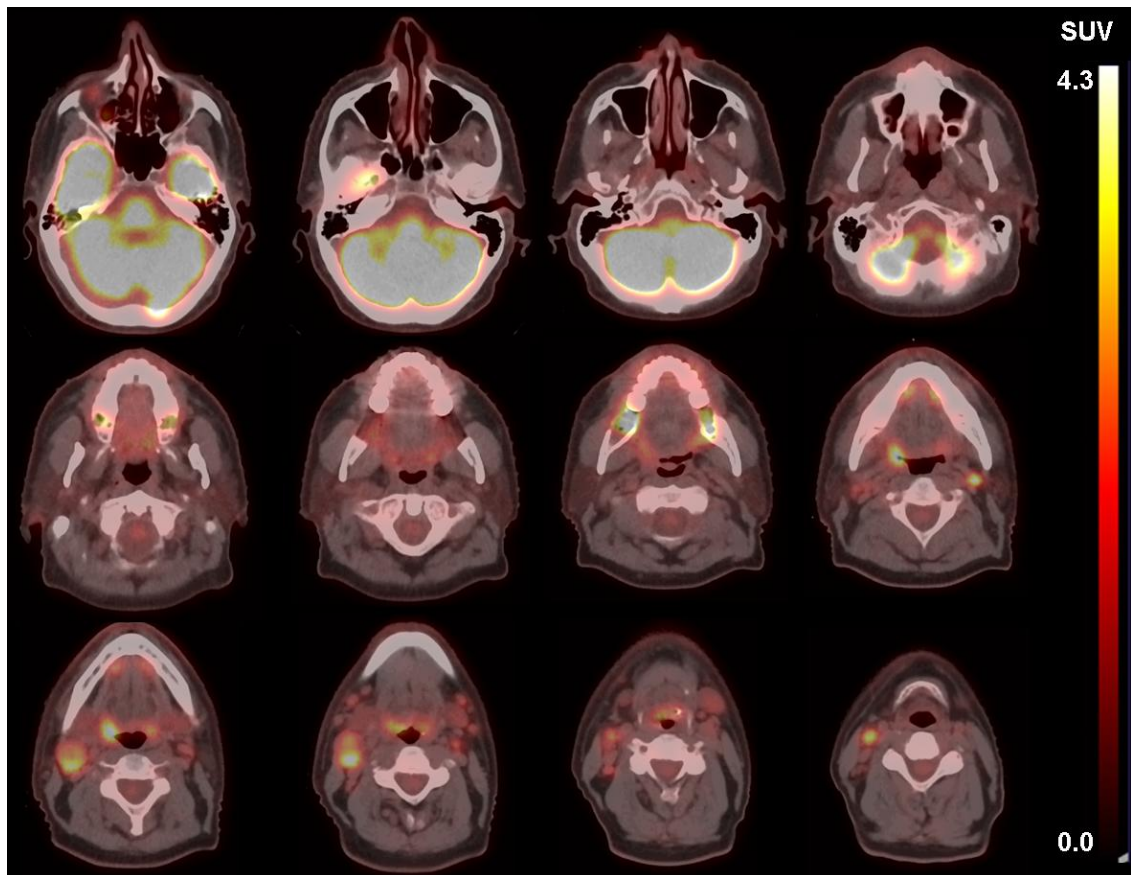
Axial sections of fused PET and CT images of head and neck region; the patient has palatine tonsil carcinoma. ^{18}F -FDG radioactivity concentration has been shown on the SUV scale. Multiple uptake areas represent higher glucose metabolism within those regions.
